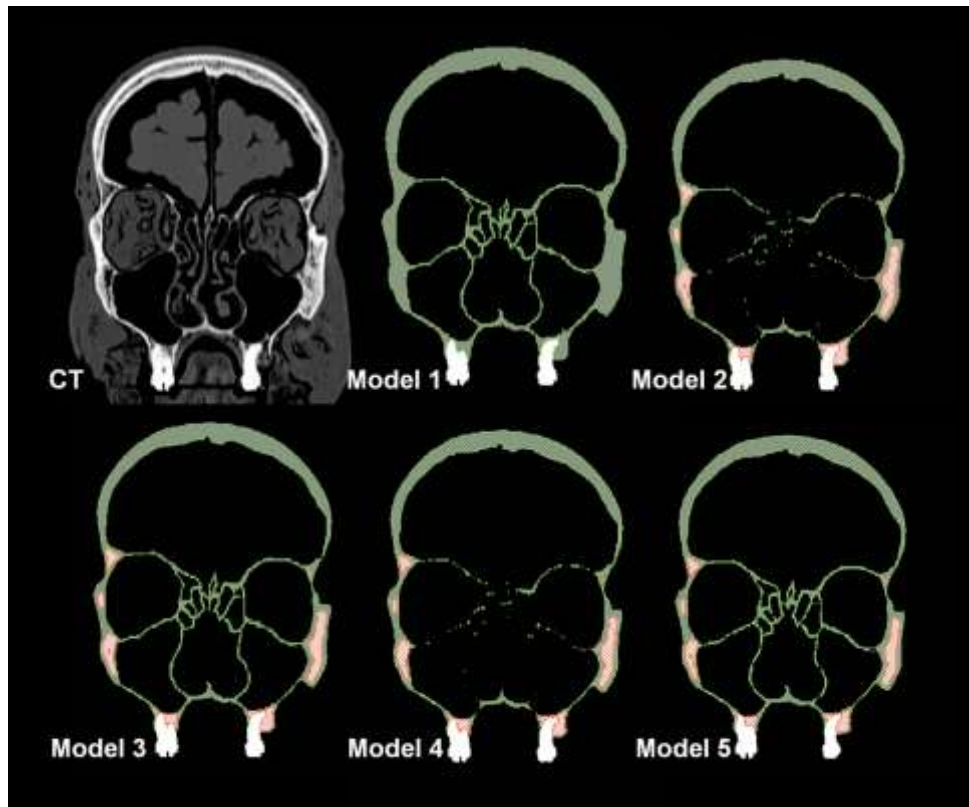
Coronal section of the original CT and the FE models showing the results produced by different segmentations. In the models green represents cortical bone, red represents cancellous bone and white represents teeth.
